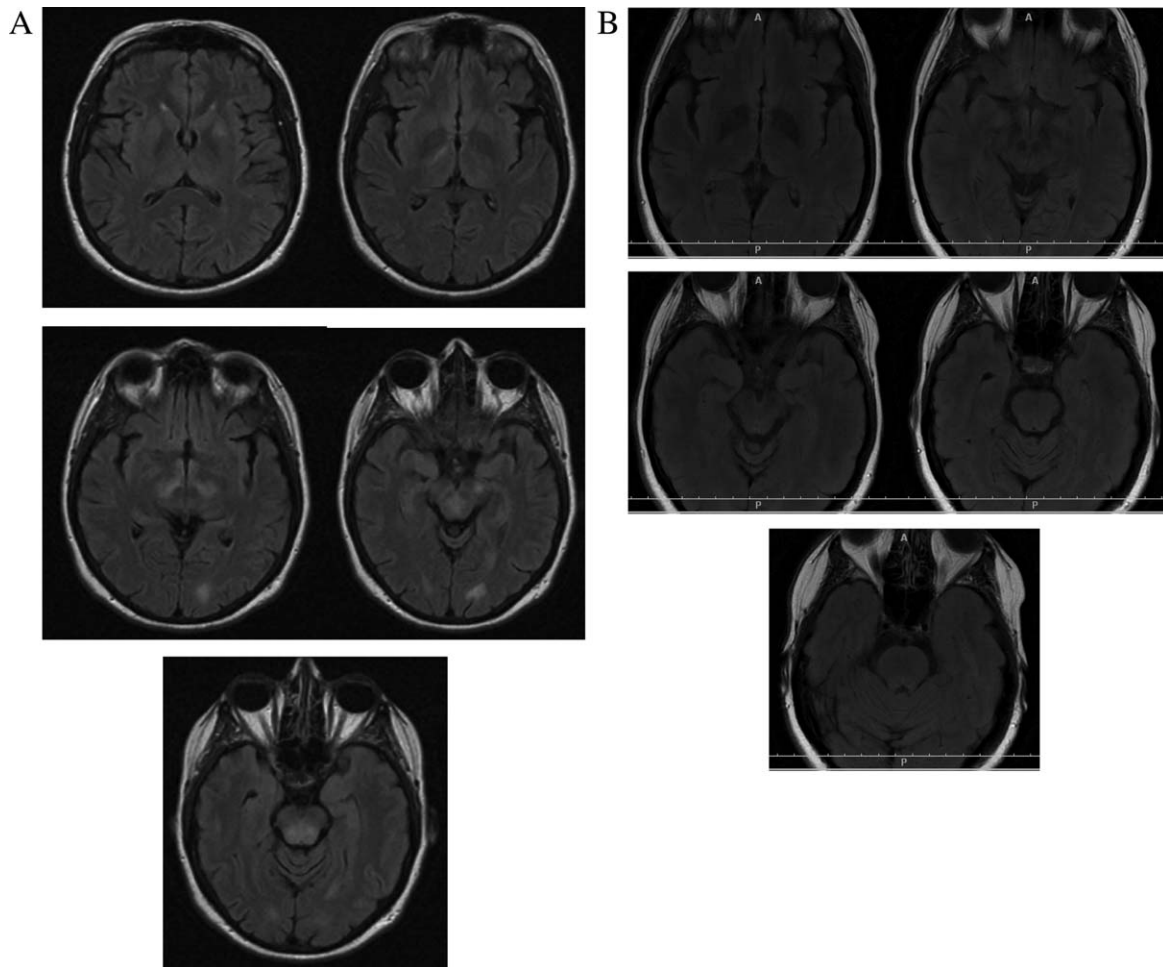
(A) Axial fluid-attenuated inversion recovery (FLAIR) MRI brain. Multiple foci of hyperintensity in the subthalamic regions, brainstem, cerebellum (not shown), left occipital white matter, and left lentiform nucleus. (B) Repeat axial fluid-attenuated inversion recovery (FLAIR) MRI brain three months after onset, showing resolution of lesions.
